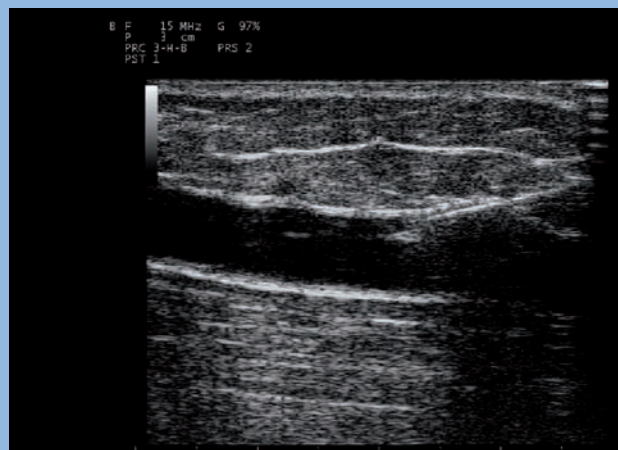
Ultrasound appearance of tip of needle within the lumen of great saphenous vein (GSV), longitudinal scan.
